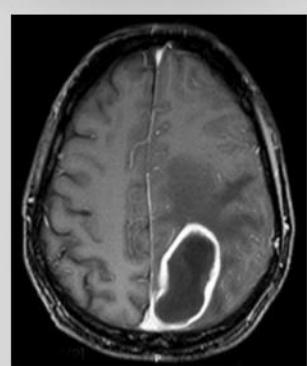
Brain MRI showing features of brain abscess.
